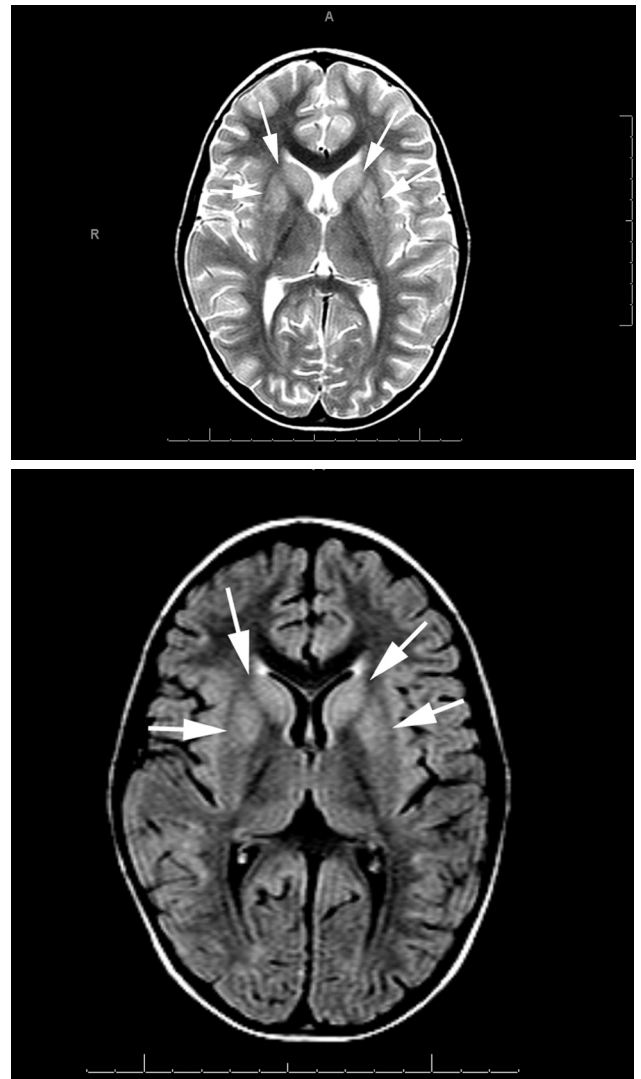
T2 weighted (a) and Fluid attenuated inversion recovery (FLAIR) sequences (b), transverse images show bilateral increased signal of basal ganglia (arrows).
